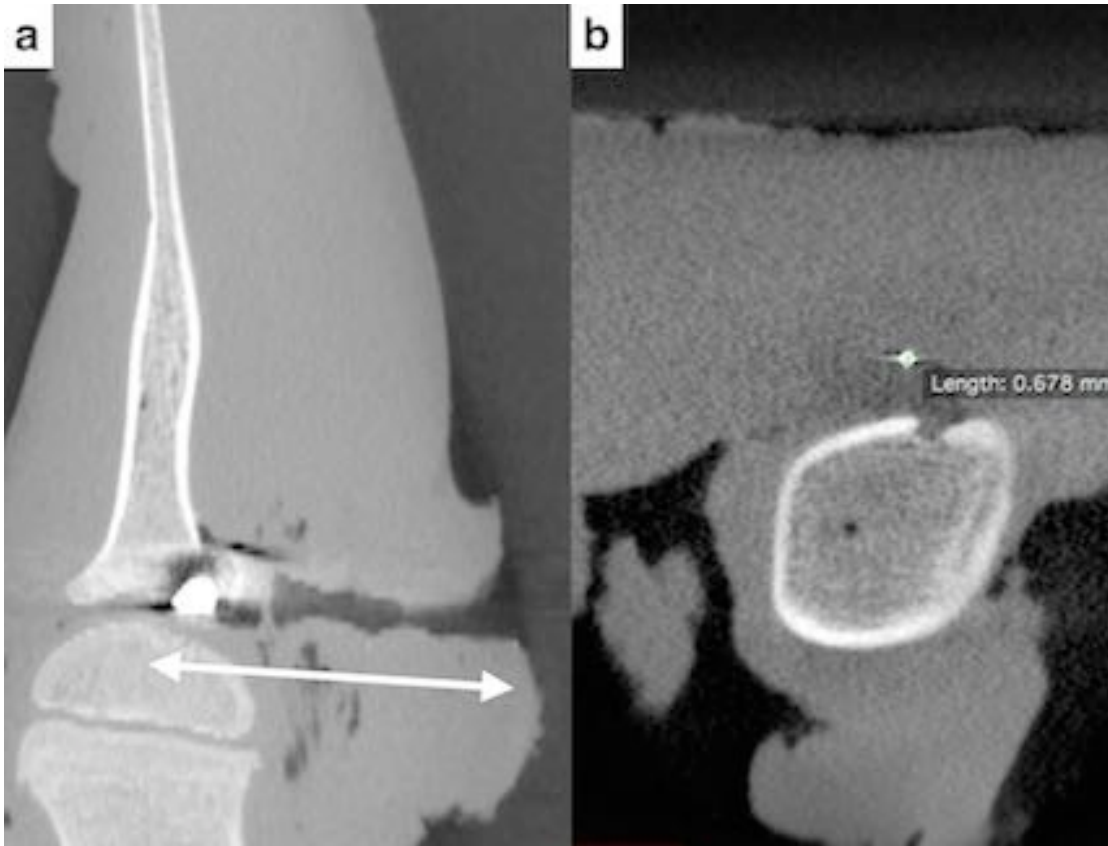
a) Depth of penetration (arrowed) measurements were discarded when bone impact (a) or fragmentation of the projectile (b) was observed on CT.
